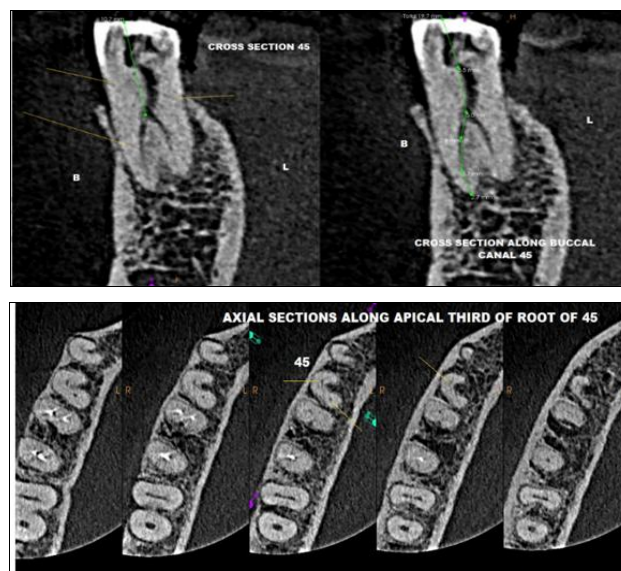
CBCT showing a single canal splitting into two - 45
